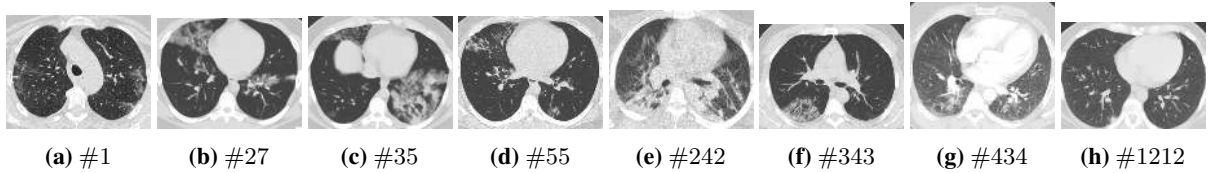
COVID-19 infected input lung CT slices [29]
